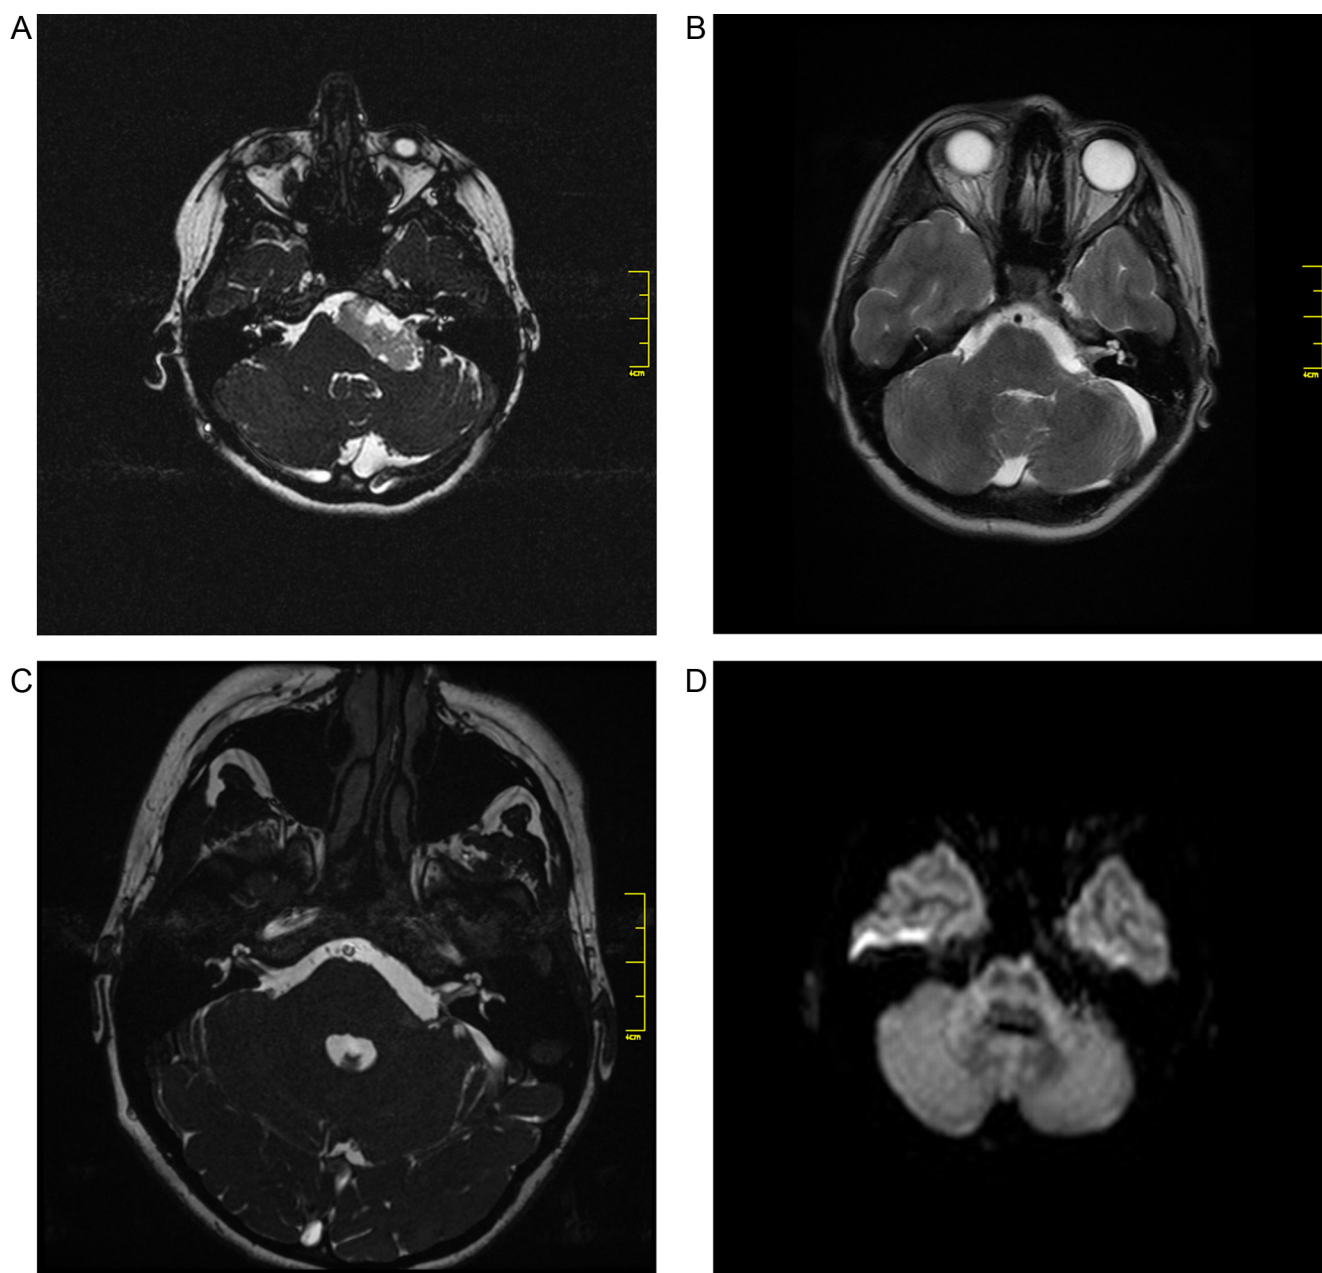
Preoperative axial MR examination in CISS sequence (A) demonstrating epidermoid cyst limited to the left cerebellopontine angle. Last follow-up MR examination obtained after complete resection shows no recurrence in T2-weighted image (B), 3D-FIESTA (C) and DWI (D) sequences.
